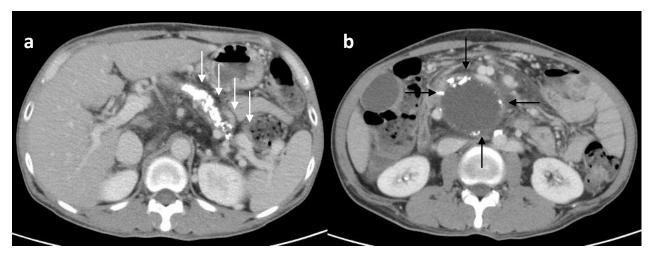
On axial reconstruction, the Abdominal CT showed calcifications in atrophic pancreas parenchyma (white arrows in figure a) and calcified pseudocyst (black arrows in figure b).
